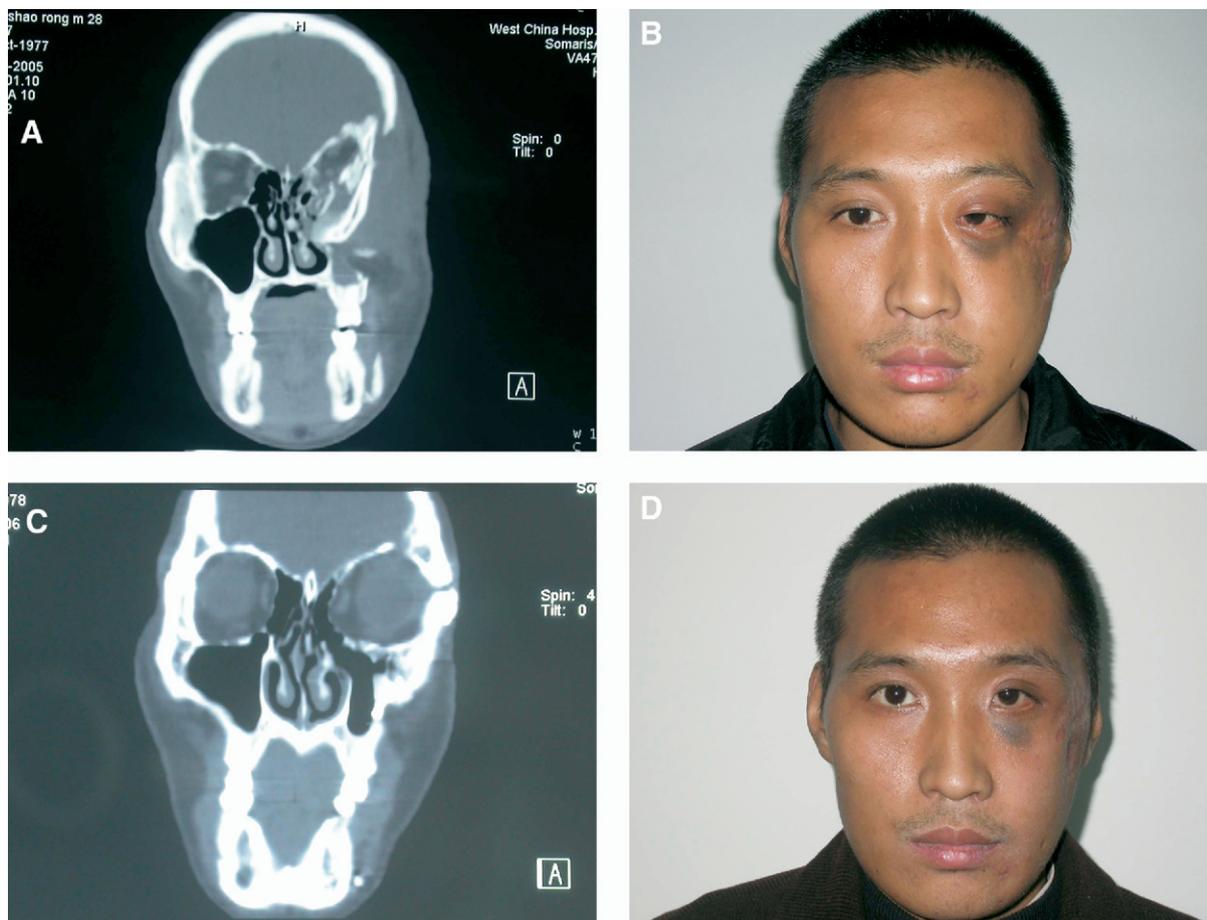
A, Case 1 coronal CT shows a large orbital floor defects with insufficient contents. It was restored with the rib. B, Preoperative photo of case 1. C, Postoperative CT of case 1. D, Postoperative photo of case 1.
